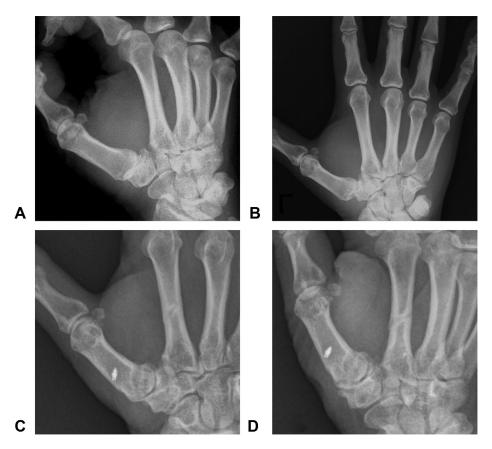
A, B Preoperative x-rays of a 58-year-old woman. Stage II Eaton-Littler with thumb subluxation and slight narrowing of the TM joint with sclerosis. C, D Postoperative follow-up at 10 years without radiological evidence of TMO progression, along with obvious reduction of subluxation.
